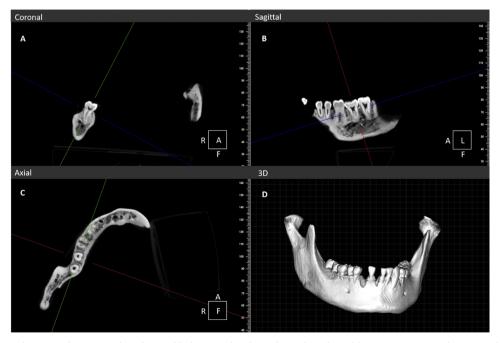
Cone beam computed tomography images of a right mandibular second molar with a C-shaped canal from an ancient sample as viewed in the coronal, sagittal, and axial directions using NNT software. A, coronal view; B, sagittal view; C, axial view; D, 3D reconstructed image.
